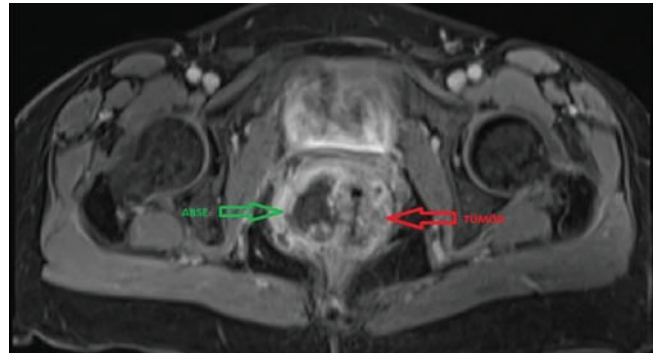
T1 postcontrast secans. The appearance of the abscess on the patient's MRI imaging.
